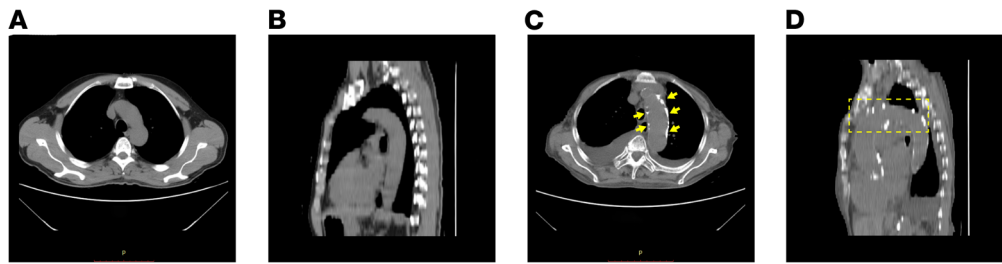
Representative images of multi-detector computed tomography (MDCT) scan of CKD patients with or without calcification. Representative axial image (A) and sagittal reconstruction (B) of contrast-enhanced CT scan in CKD patients without calcification. Representative axial image (C) and sagittal reconstruction (D) of contrast-enhanced CT scan showing aortic arch calcification in CKD patients.
